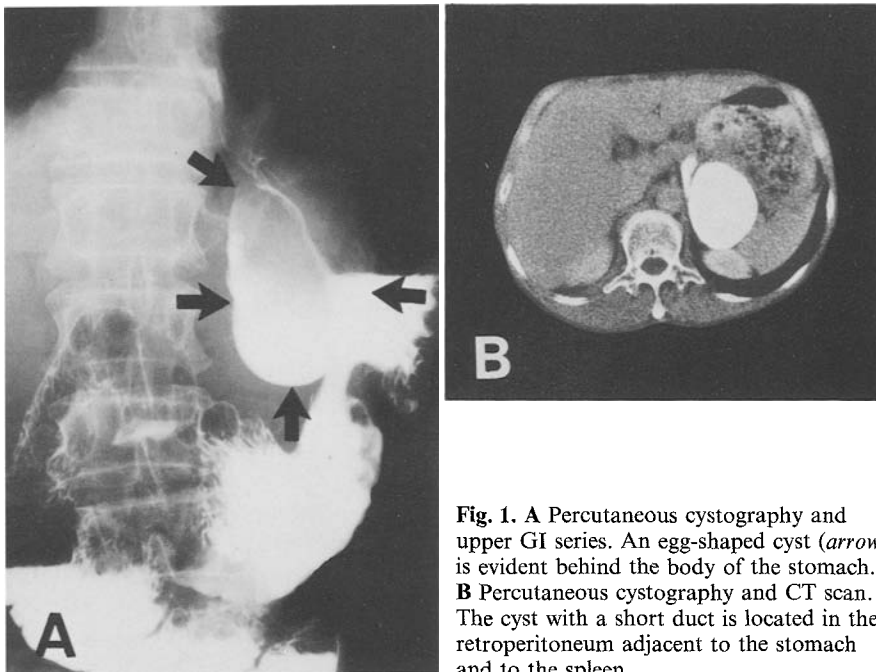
A Percutaneous cystography and upper GI series. An egg-shaped cyst (*arrow*) is evident behind the body of the stomach. B Percutaneous cystography and CT scan. The cyst with a short duct is located in the retroperitoneum adjacent to the stomach and to the spleen
